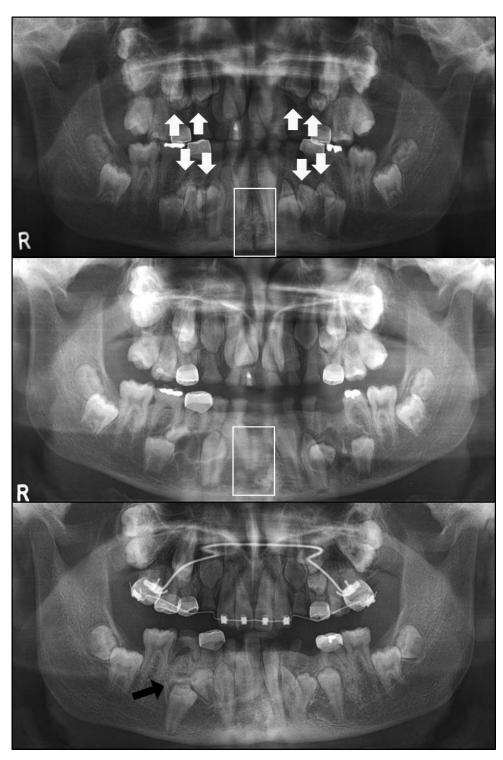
Orthopantomogram of case 7. (A) There are eight supernumerary teeth germs in the maxillary and mandibular premolar regions (gray arrow, 11 years 10 months). Delayed fusion of the mandibular symphysis is shown (white rectangle). (B) Eight supernumerary teeth were extracted (12 years 1 month). (C) One supernumerary tooth germ developed again in the lower right premolar region (black arrow, 15 years 8 months). Mandibular symphysis was fused.
